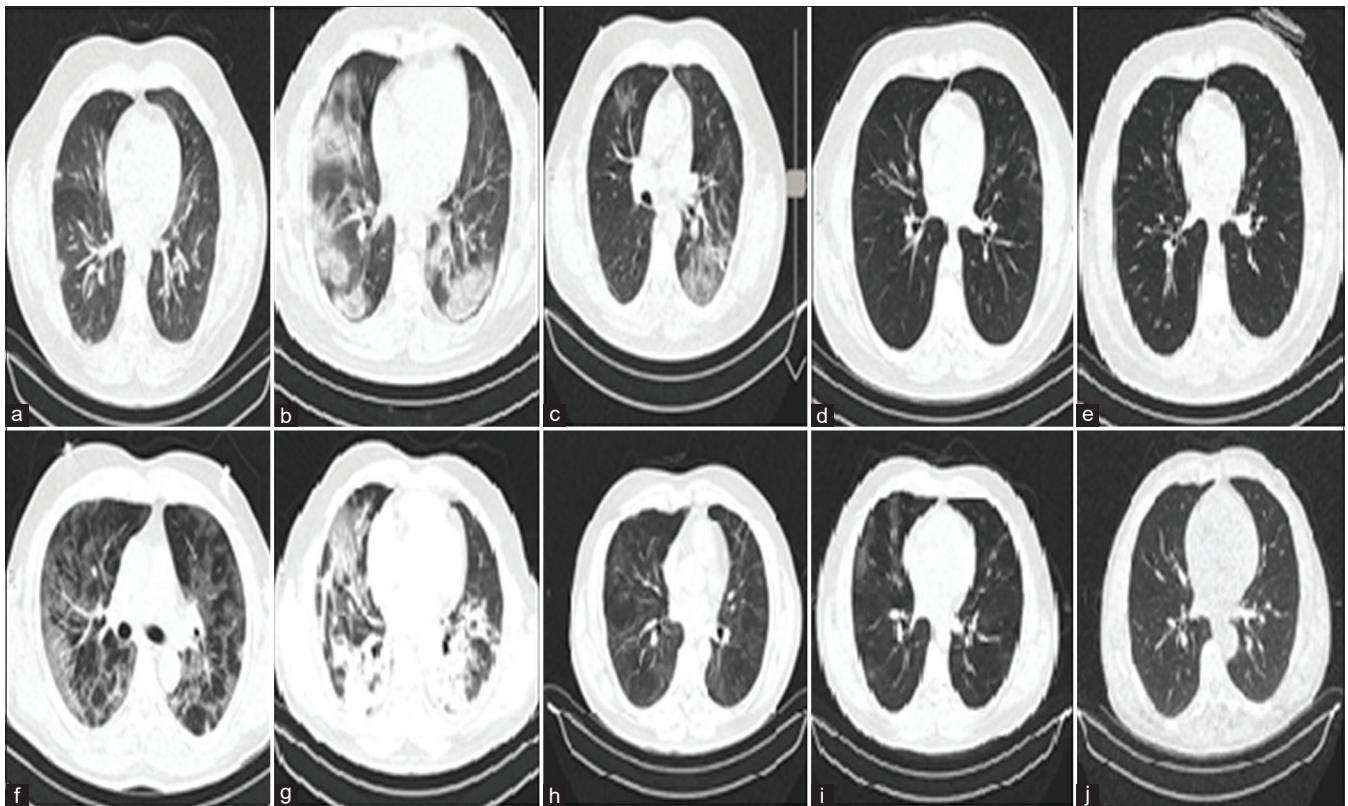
(a-d) High-resolution computed tomography (HRCT) of a 58-year-old man with COVID-19 at 3, 6, and 12-month follow-ups. (f-j) HRCT of a 43-year-old man with COVID-19 at 3, 6, and 12-month follow-ups. (a) Day 10 CT-score = 12, (b) Day 29 CT-score = 30, (c) Day 82 CT-score = 20, (d) Day 176 CT-score = 54, (e) Day 358 CT-score = 0, (f) Day 13 CT-score = 55, (g) Day 28 CT-score = 40, (h) Day 91 CT-score = 23, (i) Day 179 CT-score = 15, (j) Day 355 CT-score = 0
